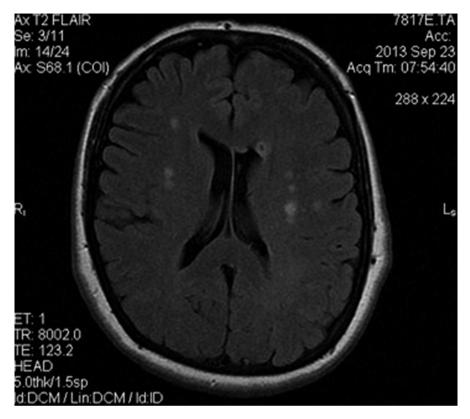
MRI showing T2/FLAIR lesions in the white matter
